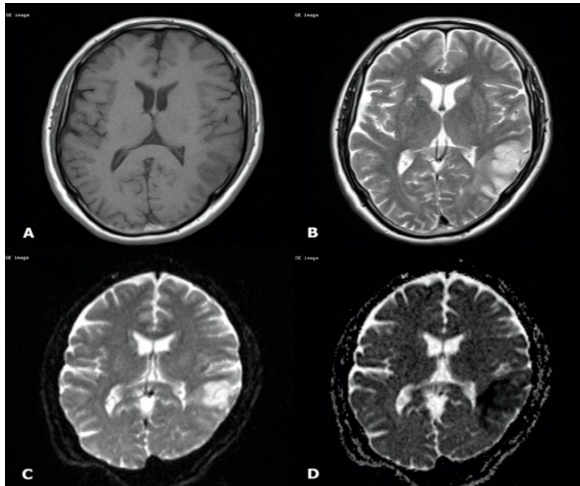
MR Imaging Findings of our 67 years old patient with cerebrovascular accident (CVA). (A) Unenhanced T1-weighted MR image shows an area of low signal intensity in the left parietal lobe. (B) T2-weighted MR image shows an area of high signal intensity in the left parietal lobe. (C) Diffusion-weighted MR image shows an area of high signal intensity in the left parietal lobe. (D) ADC map shows an area of low signal intensity in the left parietal lobe.
